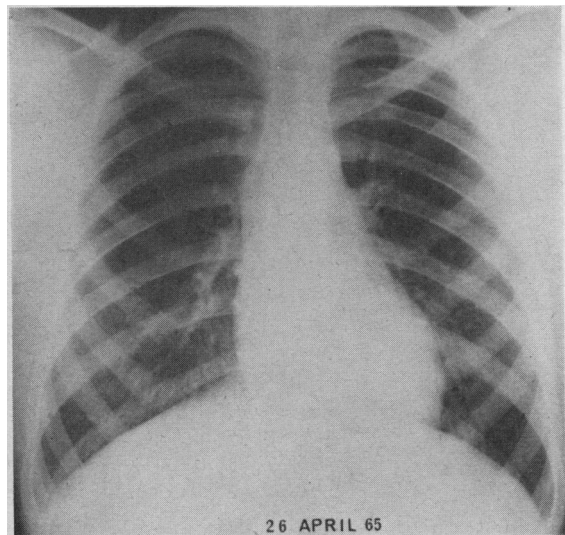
Case 4. 419th post-transplant day. One year later the chest x-ray picture was normal. Normal renal function.
